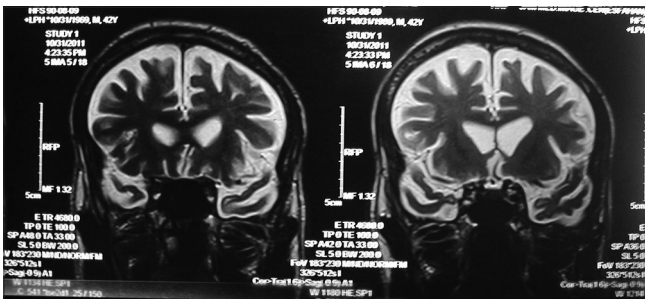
T2-weighted MRI of the patient demonstrating prominent frontotemporal atrophy
